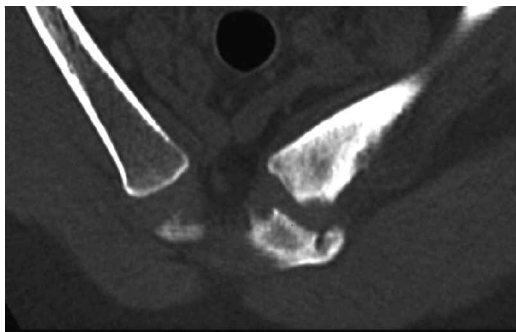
Patient 2. CT-scan through both clavicles. The left clavicle is irregular and sclerotic.
